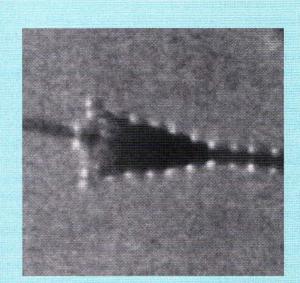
MRI image of a partially deployed nitinol stent [4].
